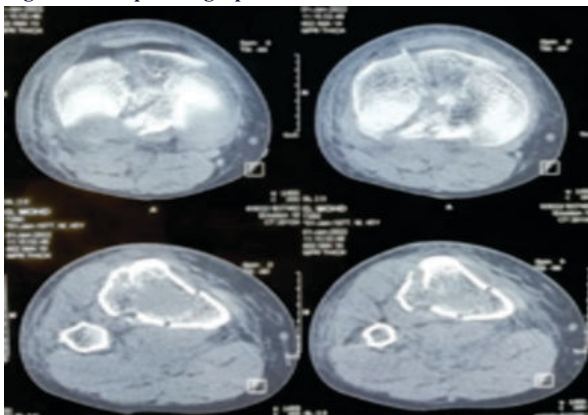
CT Axial cuts of the same patient
